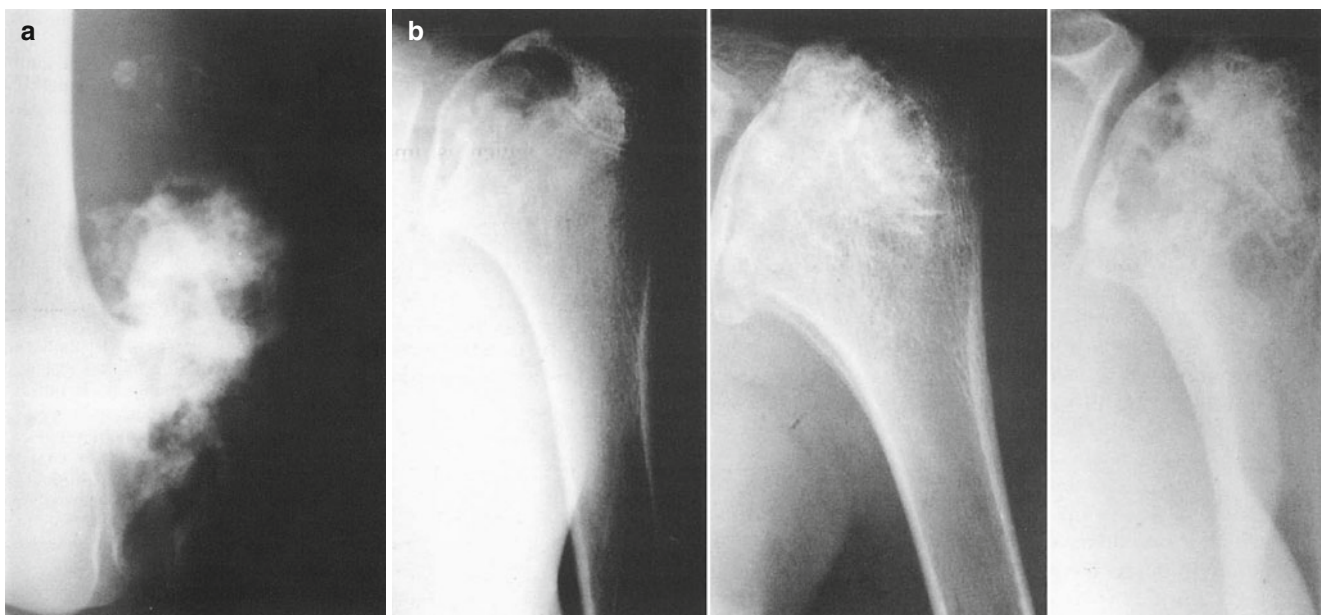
(a) Lateral radiograph showing osteochondroma of distal femur. (b) AP radiograph of proximal humerus showing chondroblastoma
